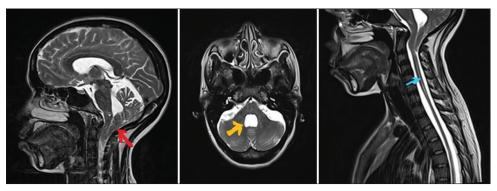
Magnetic resonance imaging findings of tonsillar herniation (red arrow), syringobulbia (yellow arrow) and syringomyelia from C3 to T1 (blue arrow)
